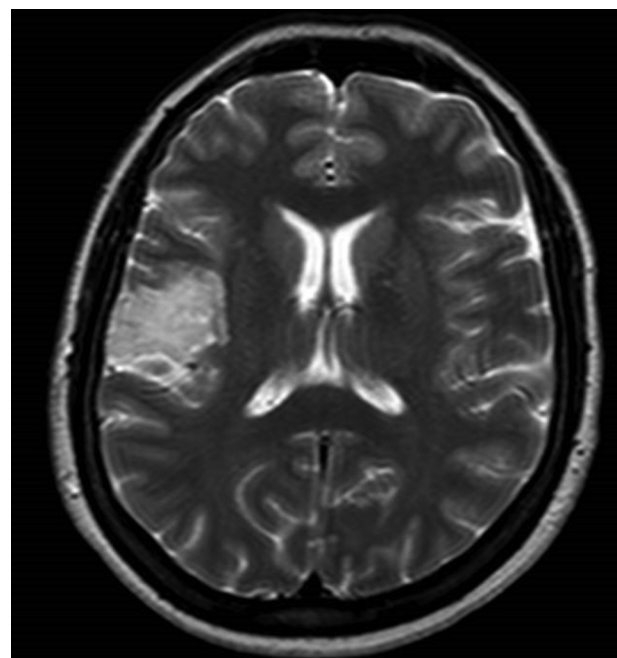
Case 2. Preoperative T2-weighted magnetic resonance imaging sequence (axial view) showing a right fronto-opercular low-grade glioma.
